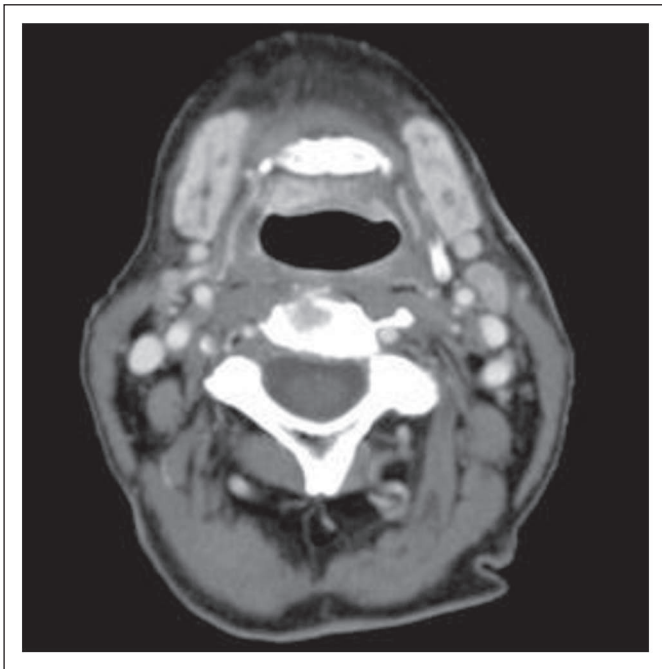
This 72-year-old patient received radiotherapy (74.8 Gy at 1.2 Gy/fraction bid) for T2N2b tonsil cancer. Postradiotherapy computed tomography demonstrated a 1.3-cm lymph node with questionable (grade 2) focal lucency in the left neck at level II. No neck dissection was performed. The patient was controlled and died of intercurrent disease with 3.5 years of follow-up.
